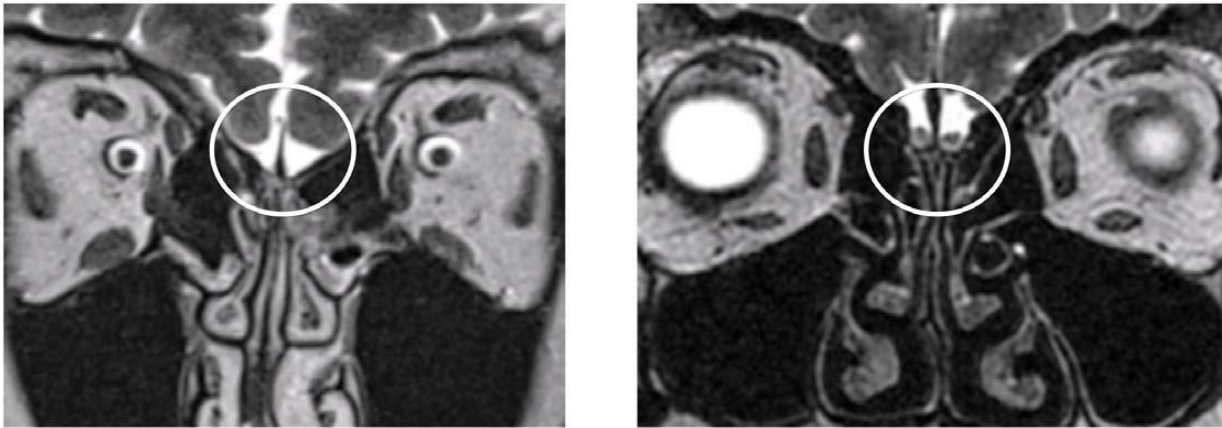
MRI image of a congenital anosmic brain (Left) with the undeveloped olfactory bulbs (circled) and a normal brain (Right) with the olfactory bulbs developed (circled)
